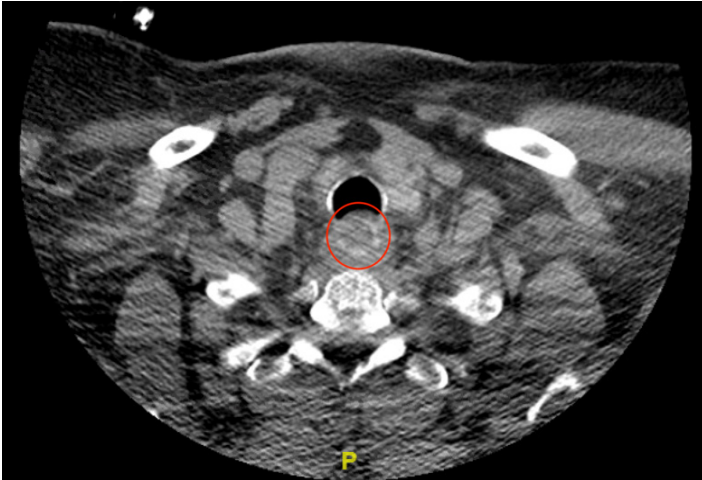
Axial computer tomography (CT) scan of the swallowed dental bridge.
